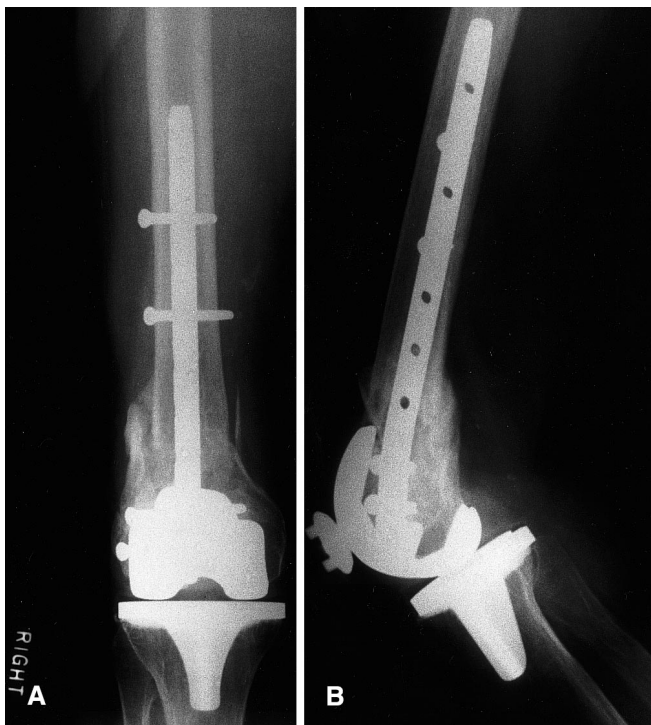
Distal femoral periprosthetic fracture in a 78-year-old female patient. A. anteroposterior and B. lateral radiographs at 6 months after supracondylar nailing. The fracture has healed in good alignment
